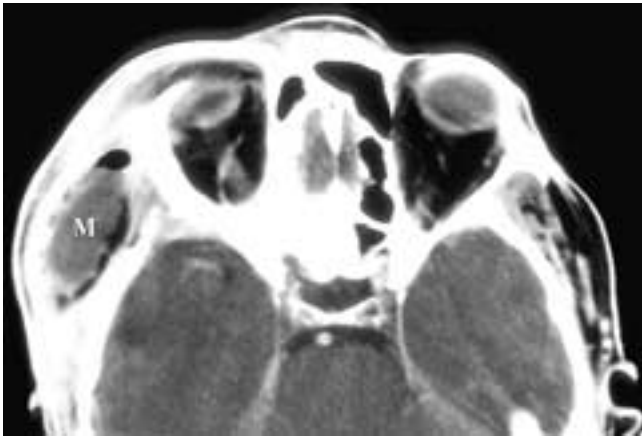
Axial contrast-enhanced CT scan through the upper facial area shows a mucoid collection (*M*) with air in the right temporal fossa adjacent to the skull. This was spread of a right masticator space abscess up into the cranial extension of the masticator space.
